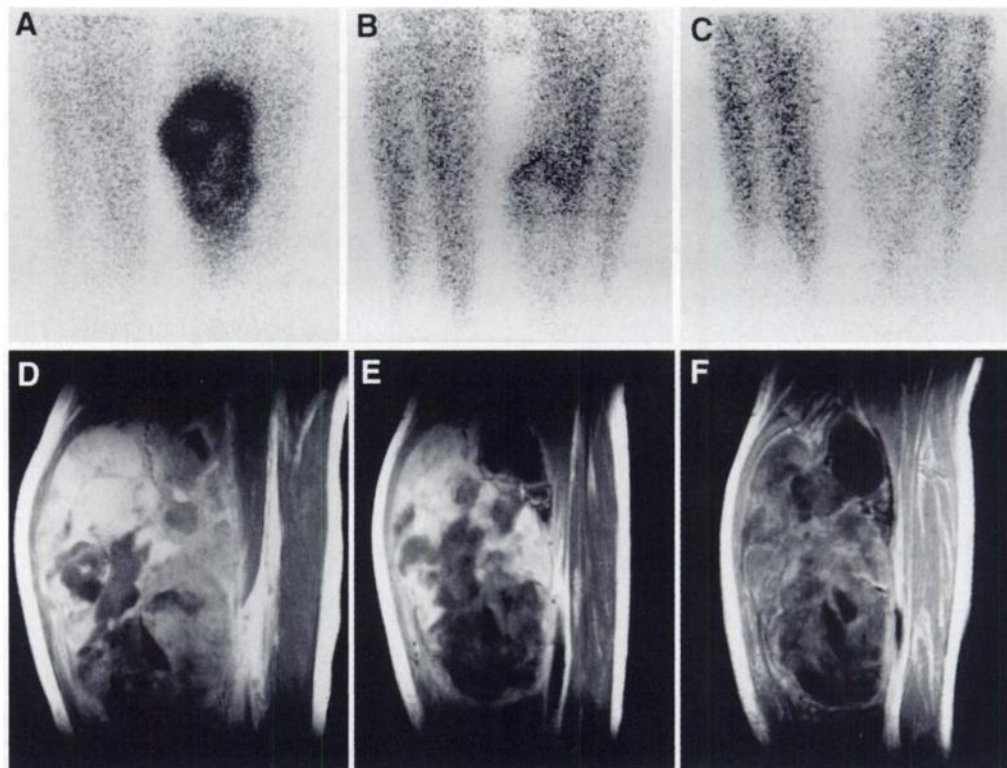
A 49-yr-old man (Patient 4) with myxoid liposarcoma in left thigh. (A) Prechemotherapeutic ²⁰¹Tl scintigraphy demonstrates increased uptake in left thigh. (B) Thallium-201 scintigraphy after three cycles of chemotherapy reveals markedly decreased uptake in the lesion. (C) After five cycles of chemotherapy, ²⁰¹Tl scintigraphy does not demonstrate any substantial uptake in left thigh, although mass lesion was still visible. Thallium-201 uptake ratios were 3.08, 1.09 and 0.71, respectively, and percent reduction was 64.6% and 76.9% for second and third studies, respectively. Complete tumor necrosis was verified after resection of tumor. (D) Prechemotherapeutic gadolinium-enhanced T1-weighted MR image demonstrates heterogeneously enhanced large mass in left thigh. (E) After third cycle of chemotherapy, mass size is decreased but enhanced lesion is still seen. (F) After final cycle of chemotherapy, no enhanced lesion is seen.
